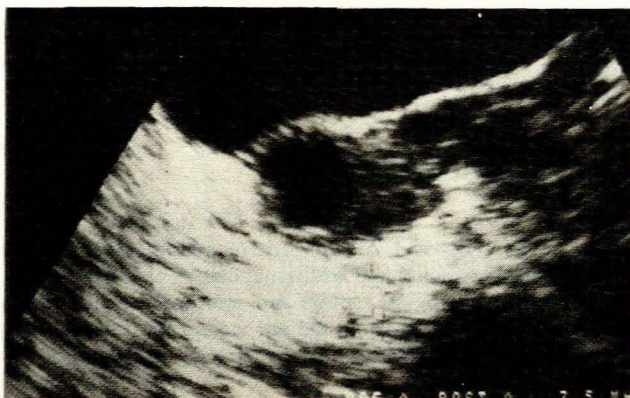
The ultrasonic image of a mature ovarian follicle with a cumulus mass prior to follicle aspiration.
